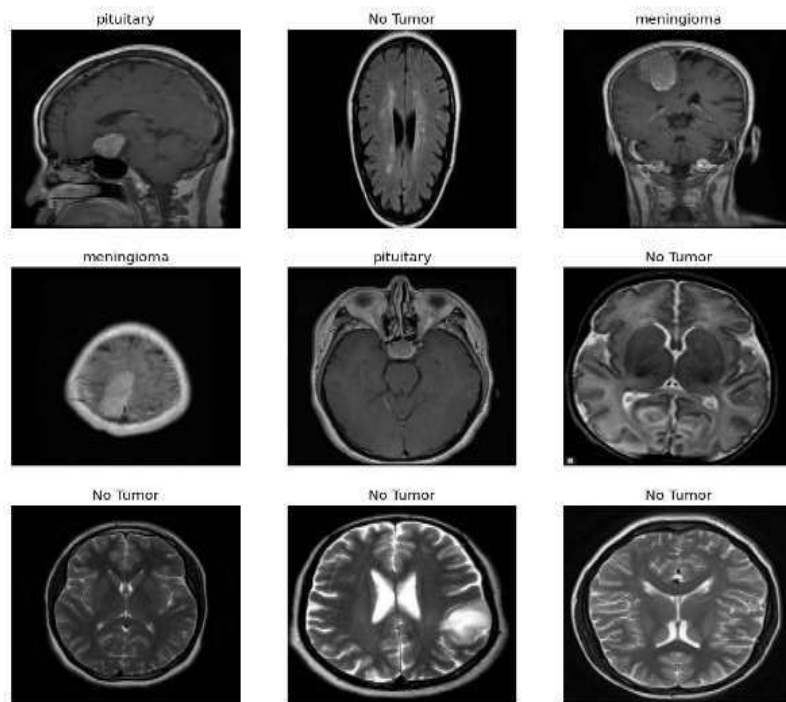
Brain Tumor MRI Dataset Samples
